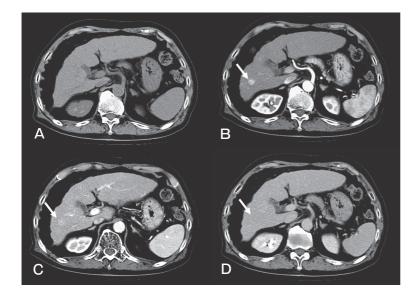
Abdominal computed tomography (CT) without contrast study (A) and with contrast study (B-D); The non-contrast CT study showed an unclear lesion (A). However, contrast CT depicted a homogeneously enhanced tumor in the early phase (B), and a tumor with lower density than the adjacent hepatic parenchyma in the delayed phase (D). The liver itself looked cirrhotic.
